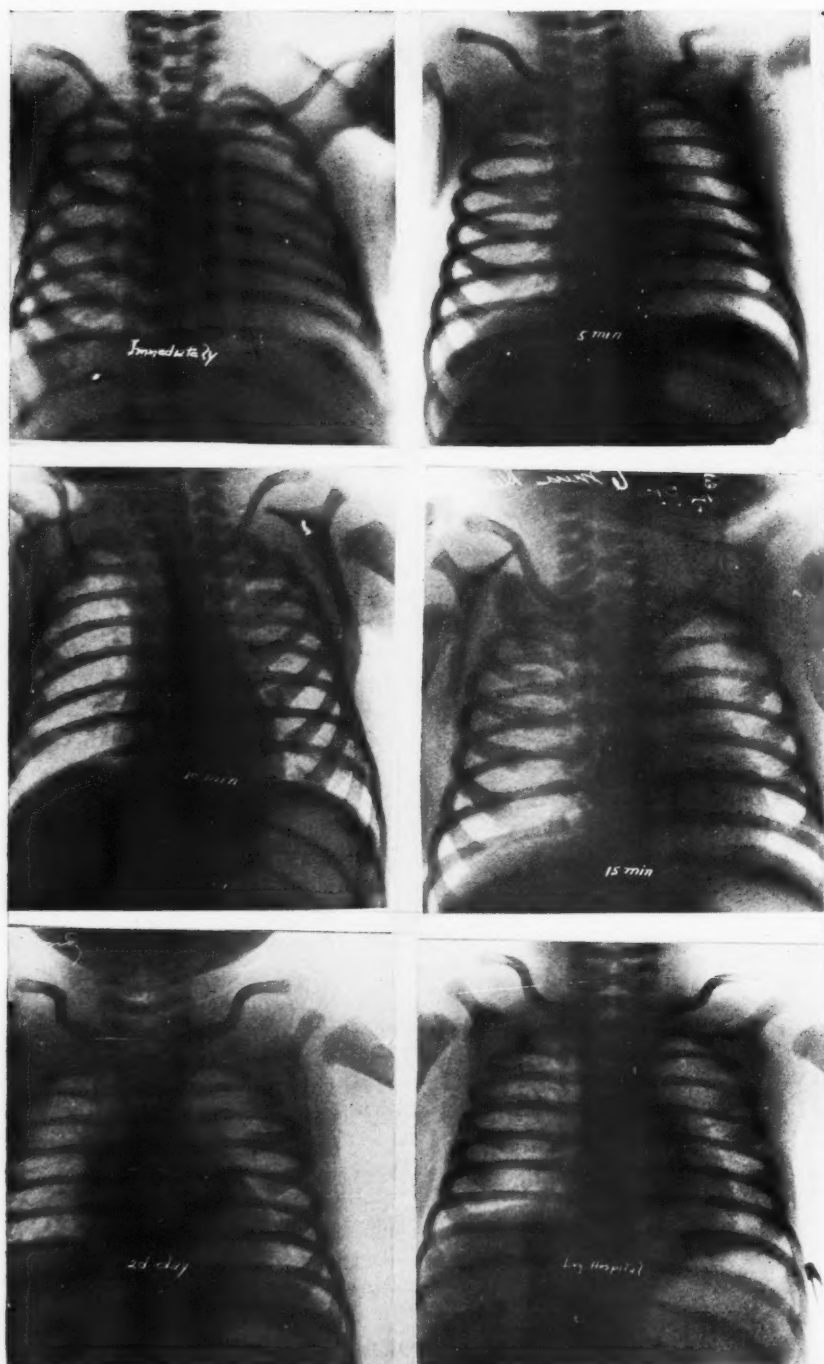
Radiographs of an infant from birth until time of leaving hospital. Note gradual expansion of lungs.
